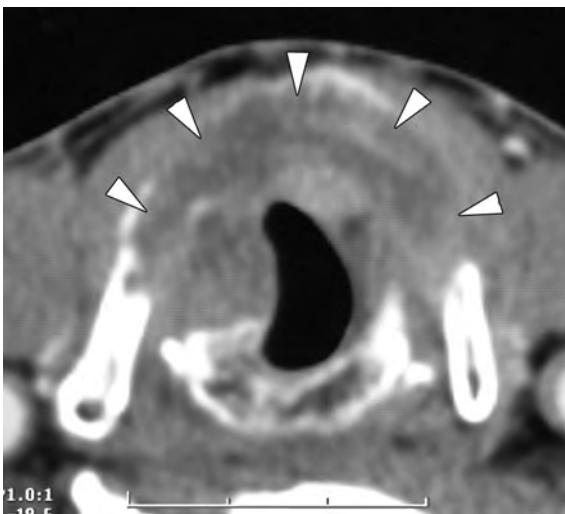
Patient presenting with history of chronic laryngitis since two years. Endoscopic examination shows edema of the anterior commissure, and scarring of the vocal cords. The axial CT-image shows thickening and distortion of the laryngeal soft tissues, as well as osteolysis and expansion of a large part of the thyroid cartilage (arrowheads). These findings are very suspect for a malignant lesion. Deep biopsy revealed squamous cell cancer
